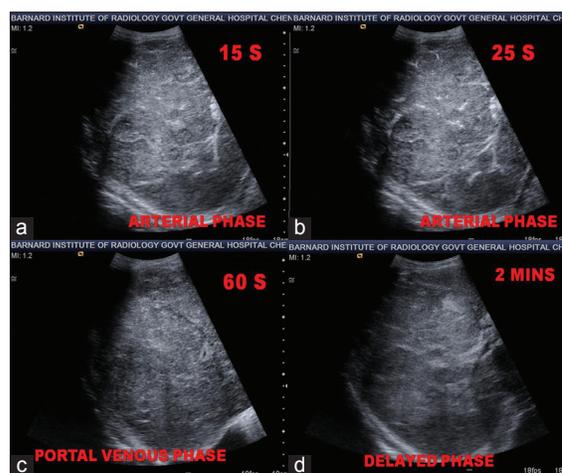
(a-d) Contrast-enhanced real-time ultrasonography - hypervascular metastasis - arterial phase: Hyperenhancing, complete; portal vein phase: Iso- to hypo-enhancing; parenchymal phase: Hypo-enhancing or washout. Hypervascular metastasis
